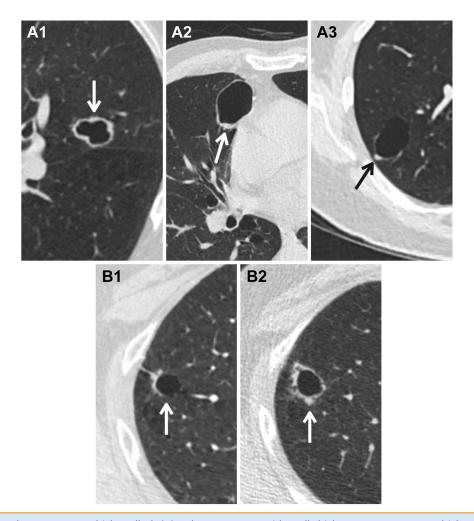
Atypical pulmonary cysts: thick walled. (A) Pulmonary cysts with wall thickness ≥ 2 mm are "thick-walled" (arrows) and are classified and managed in Lung CT Screening Reporting and Data System (Lung-RADS) v2022. Wall thickness may be circumferential (A1), asymmetric (A2), or focal (A3). Thick-walled cysts are classified as Lung-RADS 4A. (B) A 62-year-old patient at baseline screening CT with a thick-walled cyst (arrow, B1)—Lung-RADS 4A. The nodule was stable at 3-month follow-up and returned to annual screening per Lung-RADS v1.1 management. At annual screening, the atypical pulmonary cyst had increased in size with increased wall thickness and new nodularity (arrow, B2). The patient underwent surgical resection with a confirmed diagnosis of adenocarcinoma. In Lung-RADS v2022, thick-walled cysts with growing wall thickness or nodularity are classified as Lung-RADS category 4B.
